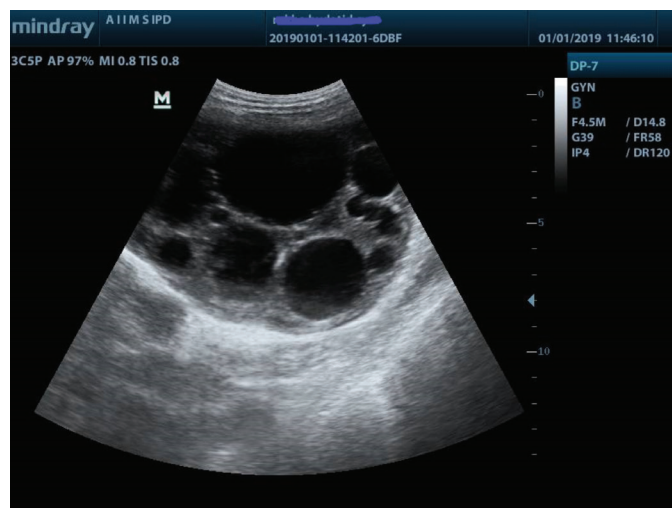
Ultrasonography pelvis showing multiseptated cystic lesion with multiple small cysts within both adnexae
